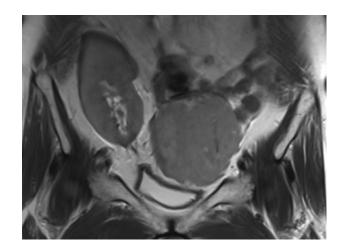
Coronal T2 Fast Spin Echo (FSE) one month after the CT demonstrates the T2 intermediate uterine mass which had increased in size to 8.0 x 7.4cm.
